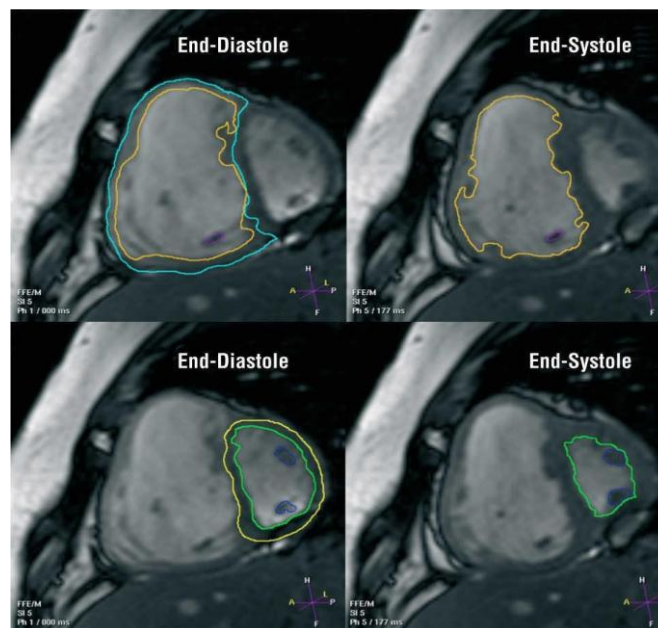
Magnetic resonance imaging (MRI) for Pulmonary Hypertension (20)
